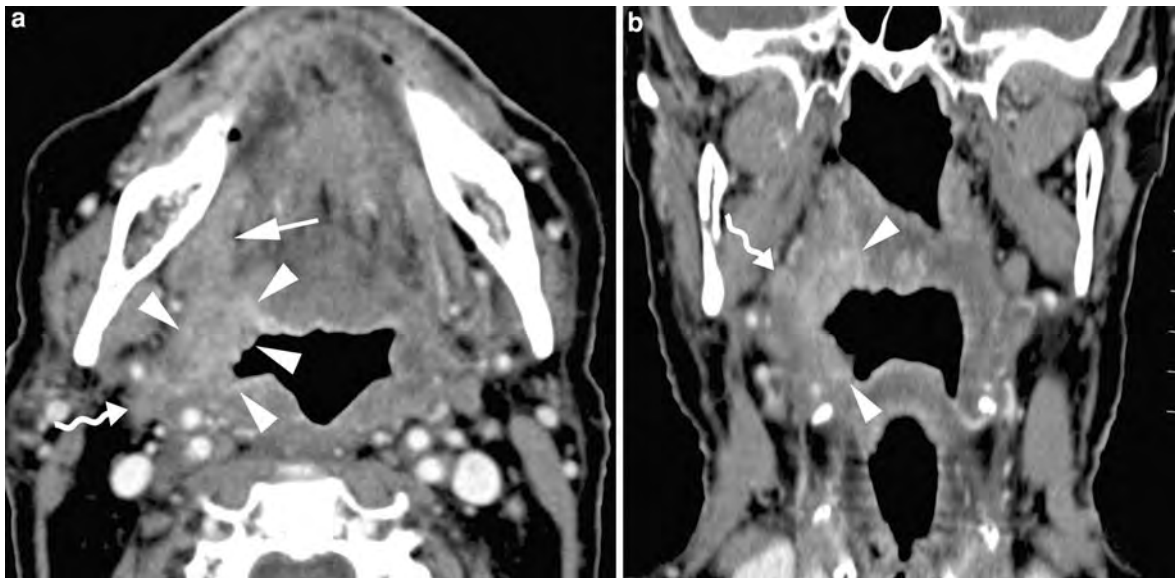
Patient treated by irradiation for right-sided tonsillar cancer 5 years earlier; clinically an area suspicious for recurrent cancer is seen on the right tonsil. a Axial contrast-enhanced CT image. Area of soft tissue thickening and increased enhancement in right tonsillar area, extending into tongue base (*arrowheads*): recurrent cancer. Some anterior extension along the hyoglossus muscle is suspected (*arrow*). The lesion abuts the styloglossal muscle, which has a slightly irregular contour (*curved arrow*).
